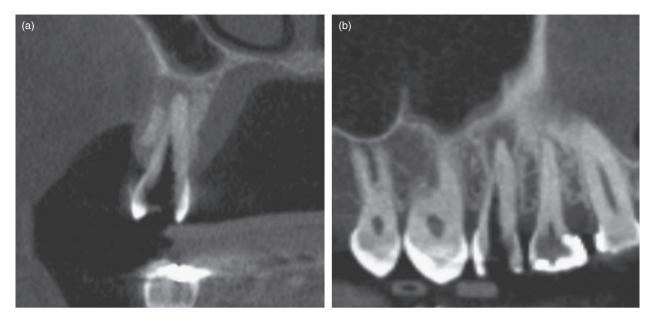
CBCT showing suggestive images of bone resorption in the periapical region and perforation in the apical third.
